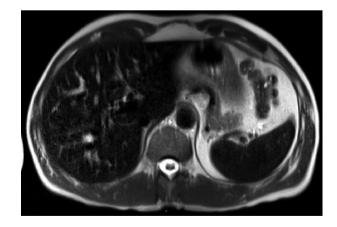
Hepatic and splenic iron accumulation in a kidney transplant recipient 3 years after transplantation. T2-weighted magnetic resonance imaging show marked reduction of signal intensity of the liver and spleen, which should normally appear isointense with the signal from the dorsal muscle.
